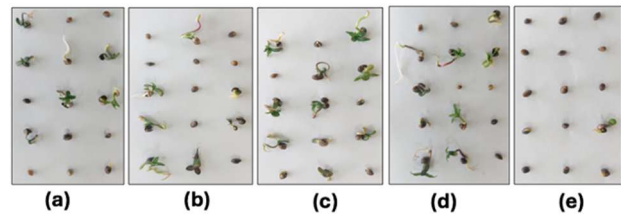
Seeds were treated with ultrasonic waves for (a) 0 min, (b) 10 min, (c) 20 min, (d) 30 min, (e) 40 min, and sown on a wet kitchen towel. Results after 7 days of sowing.
